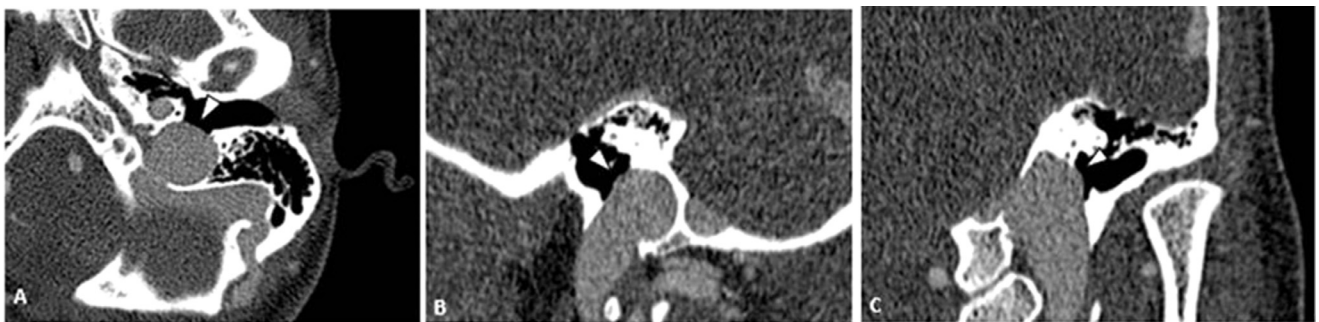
Contrast computed tomography of the left ear of the same patient, in axial (A), sagittal (B), and coronal (C) view by multiplanar reformatting, where sigmoid plate dehiscence is observed (white arrowhead).
